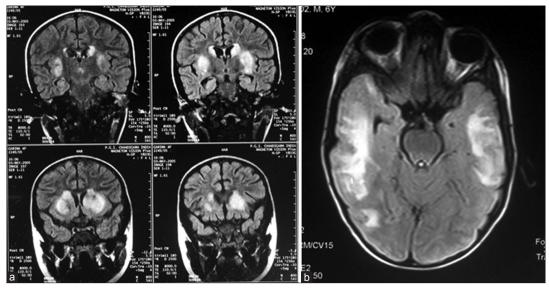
Magnetic resonance imaging brain of patient with acute demyelinating encephalomyelitis (ADEM) showing extensive hyperintensities in fluid-attenuated inversion recovery sequence. (a) Extensive hyperintensities involving periventricular white and deep grey matter involvement including thalamus and basal ganglia. (b) Diffuse white and grey matter involvement which is asymmetrical (these patients diagnosed as ADEM)
